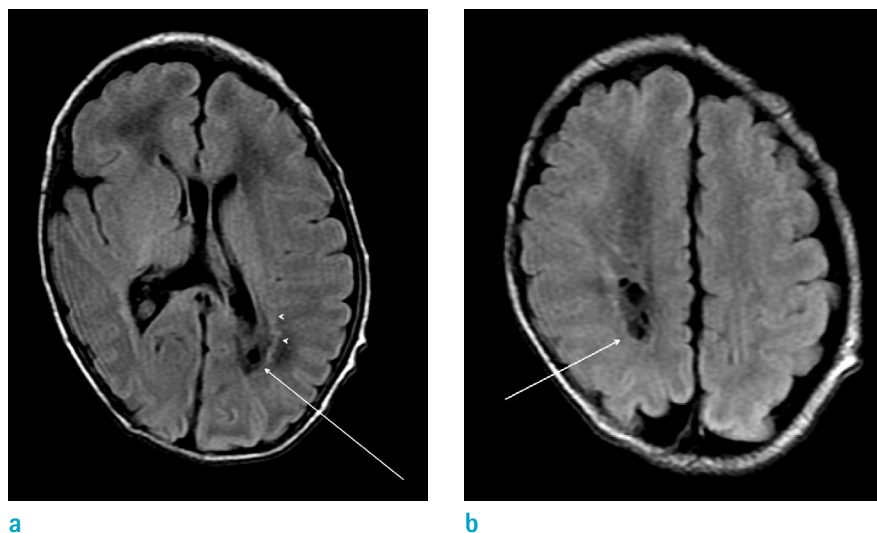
(a, b) Cystic encephalomalacia (arrows) and punctate lesions (arrowheads) were seen in the parietal white matter. This male infant was born at 30+6 weeks with birth weight of 1620 g. MRI was performed at 38+2 weeks. He had PDA clipping. He showed delayed mental and psychomotor index at 2 years.
